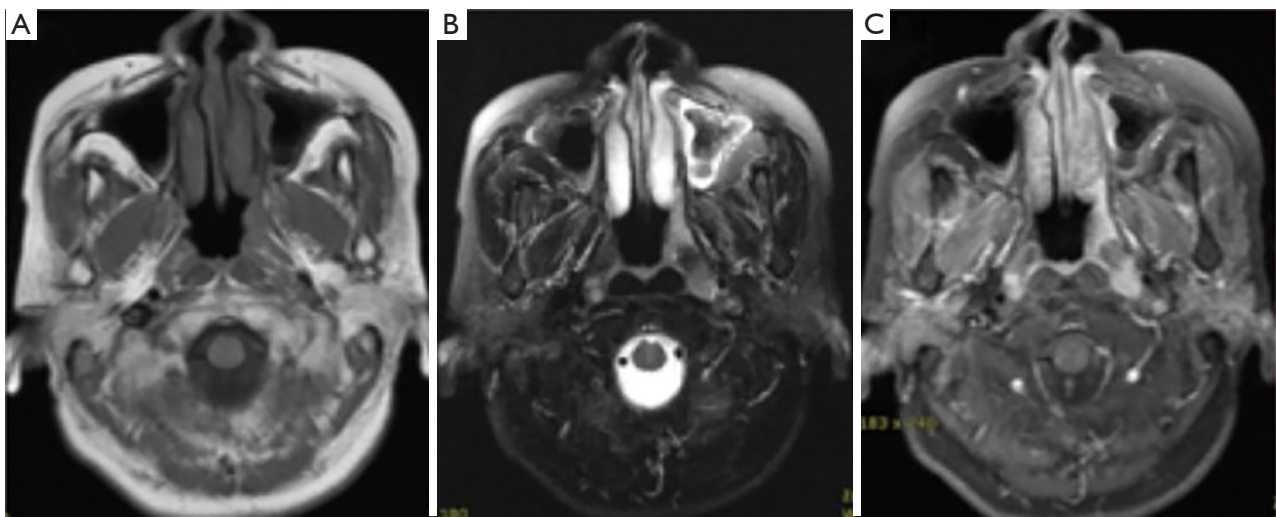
This is a transverse view of patient's head and neck MRI at diagnosis. (A) T1W image (T1 weighted image) (B) the picture showed T2W image (T2 weighted image) (C) the picture showed T1W SPIR image (short tau inversion recovery phase), a 2.0 cm × 1.3 cm hypointense lesion over the nasopharynx
